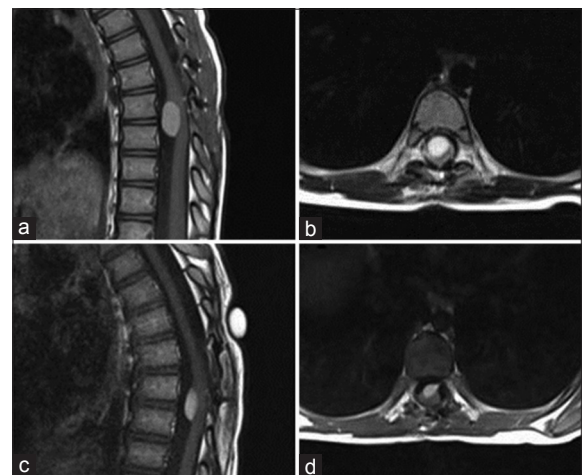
First month control magnetic resonance imaging revealed the rest mass almost the half volume of the preoperative mass (a and b), the 3rd year magnetic resonance imaging revealed the size of the lipoma half of postoperative size (c and d)
